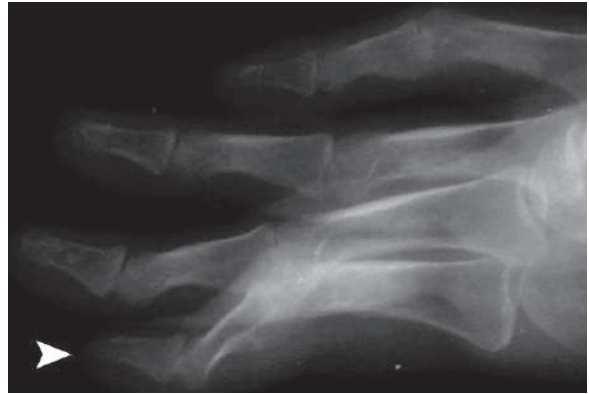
Lateral plain radiograph of the fingers of a patient with RA shows Boutonnière deformity (*arrowhead*)
